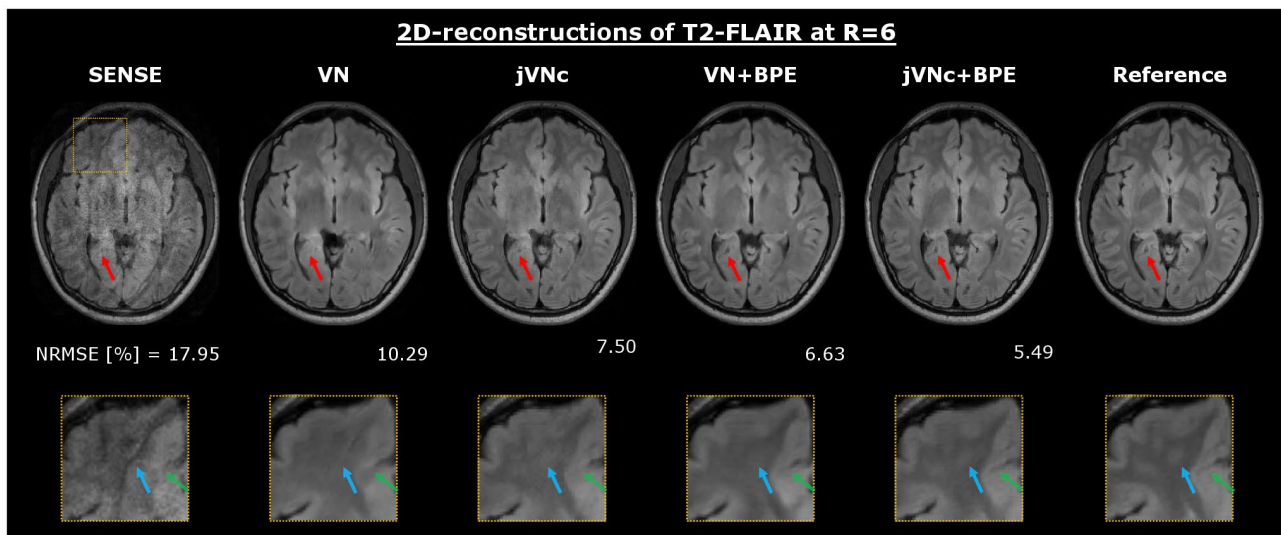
At $R = 6$ -fold acceleration, the $SENSE$ reconstruction of T2-FLAIR resulted in large noise amplification and aliasing artifacts, which were mostly mitigated using the single-contrast VN . However, by reconstructing T1w, T2w and T2-FLAIR-weighted contrasts jointly ($jVNc$) or utilizing BPE ($VN + BPE$), fine anatomical details were better preserved and the over-smoothing reduced. The overall best performance was achieved by $jVNc + BPE$ which is also reflected in the lowest NRMSE (computed across 36 slices)
